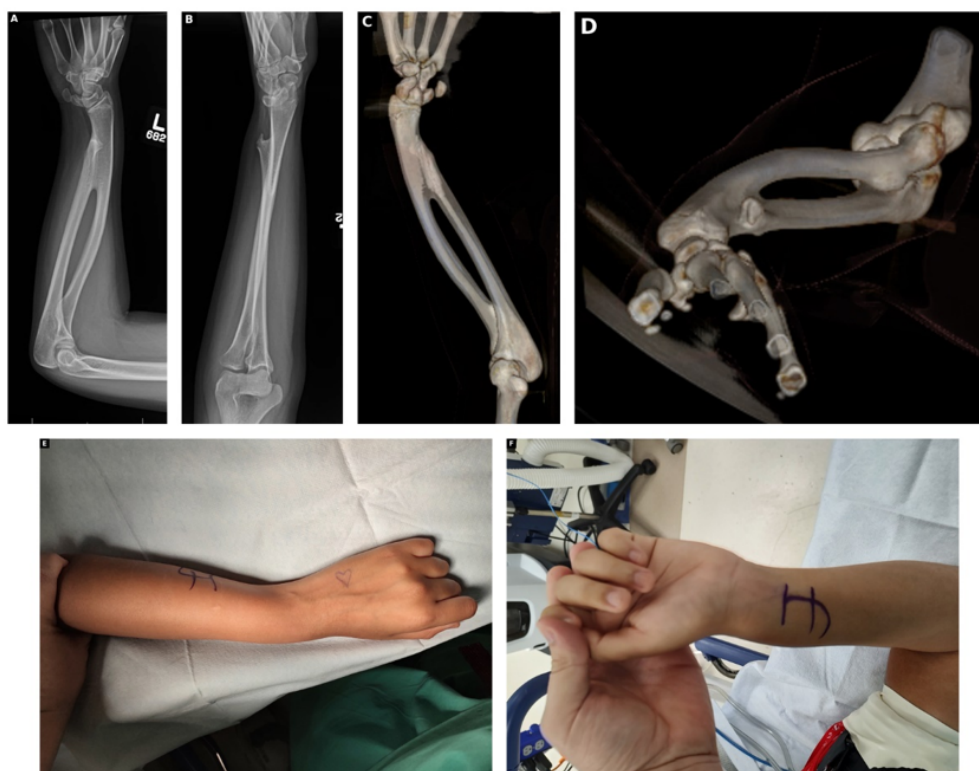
Preoperative imaging of the left forearm. (A, B) Anteroposterior and lateral radiographs showing osseous fusion of the distal radius and ulna with marked radial shaft bowing and negative ulnar variance. (C, D) Three-dimensional CT reconstructions of the synostosis and forearm deformity. (E, F) Clinical photographs demonstrating the deformity and fixed loss of rotation.
